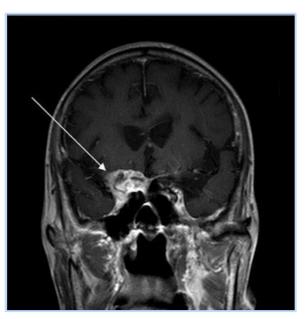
Coronal MRI showing a mass in the right cavernous sinus, extending to the anterior cranial fossa and the superior orbital fissure.¹¹
